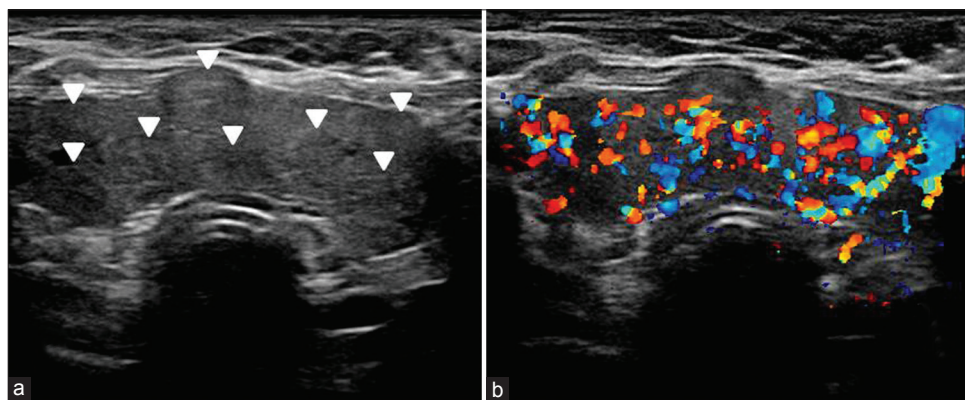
Multinodular goiter. Transverse gray-scale ultrasound (a) and color Doppler (b) neck, of a 50-year-old female patient, shows enlargement of both thyroid lobes and isthmus by multiple iso-hyperechoic solid nodules (arrowheads). Note, marked increase in vascularity within the gland. (Reproduced with permission from Indian Journal of Endocrinology and Metabolism)
